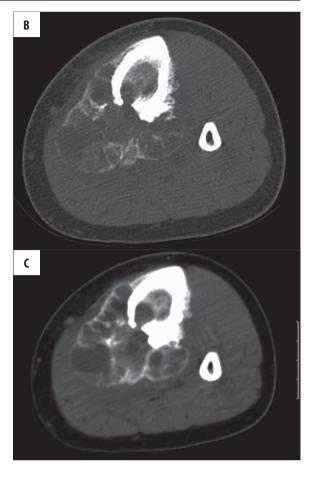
Patient O.P. (A) Plain film. Suspicion of a malignant lesion: irregular osteolytic defect, ill-defined periosseous mass, Codman's triangle, spicular periosteal reaction. (B,C) CT. ABC: sclerotic rim, septa, fluid levels (B – bone window, C – soft tissue window).
